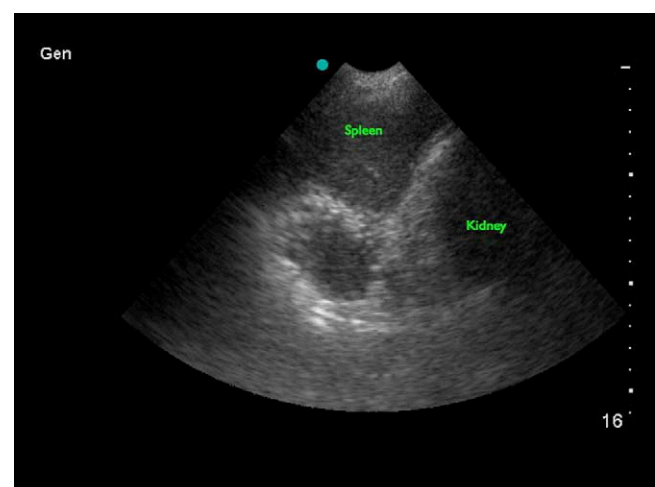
Ultrasound image of the left upper quadrant.
